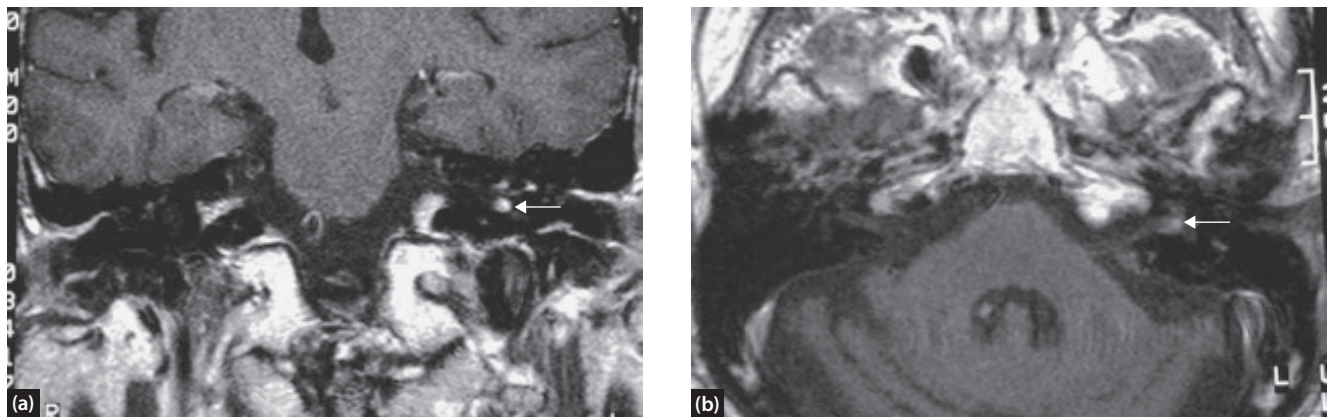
(a) Coronal and (b) axial MRI of a patient with a left-sided idiopathic palsy. Increased signal is clearly visible in the geniculate region (arrowed).
